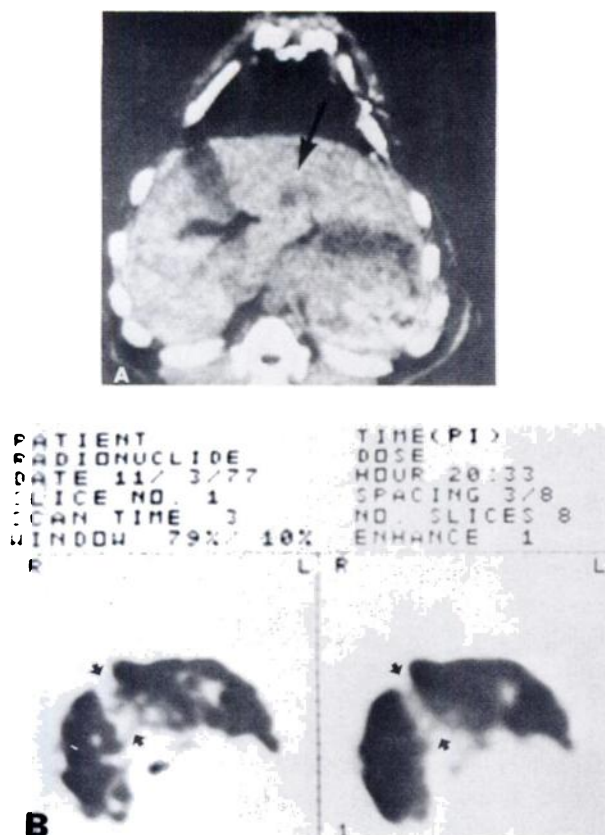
(A) Hematoma, demonstrated by transmission CT as area of low attenuation within left lobe of liver (arrow). (B) Hematoma within left lobe of liver, visualized by emission (Tc-99m SC) computed tomography. Note location of gallbladder fossa and porta hepatis (arrows). Raw data on left; processed image on right.
